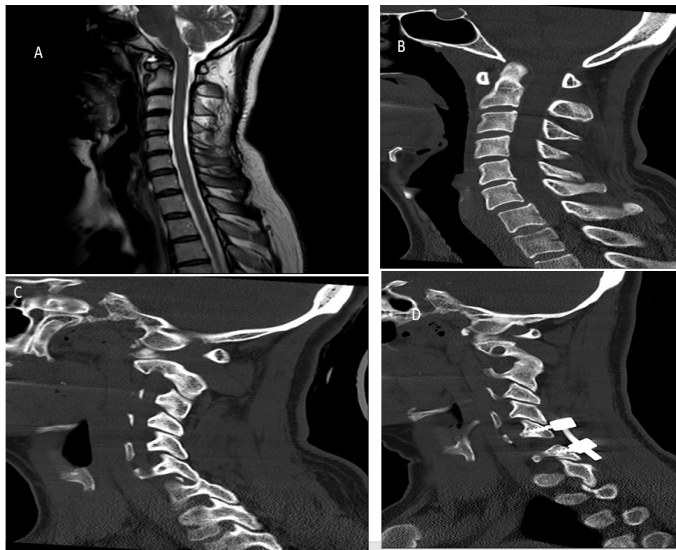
Radiological imaging of a patient operated posteriorly with unilateral facet joint dislocation. A) Preoperative midsagittal T2-weighted MRI section shows no abnormalities. B) Preoperative midsagittal CT section shows slight anterolisthesis. C) Preoperative sagittal CT section shows dislocated facet joint at C6-7 levels. D) Postoperative CT shows reduction of facet joints and posterior fusion material at the operated level
